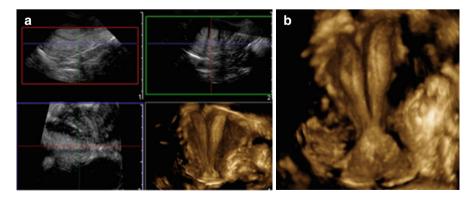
Complete septate uterus: transvaginal 3D ultrasound showing endometrial echo as a "V"-shaped image; the uterine cavity with a hypoechoic middle septum. (a) 3D multiplanar images for 3D reconstruction 1,2,3. (b) Displaying a 3D image
